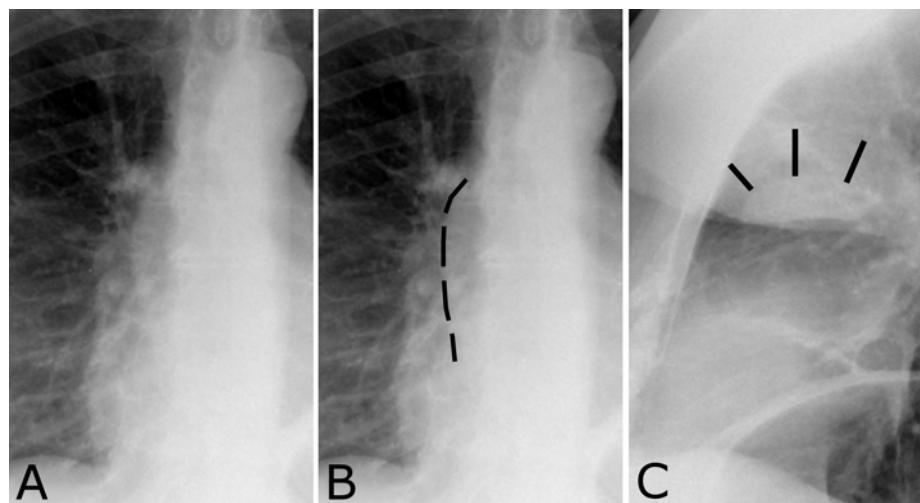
Anterior mediastinal mass. A. Unmarked frontal film. B. Marked film to show the border of the mass (black dashes). C. Lateral radiograph to show that the mass (black lines) is centered in the anterior mediastinum, but you must always consider that it may have had a middle mediastinal origin or it may be a lung cancer invading the mediastinum.
